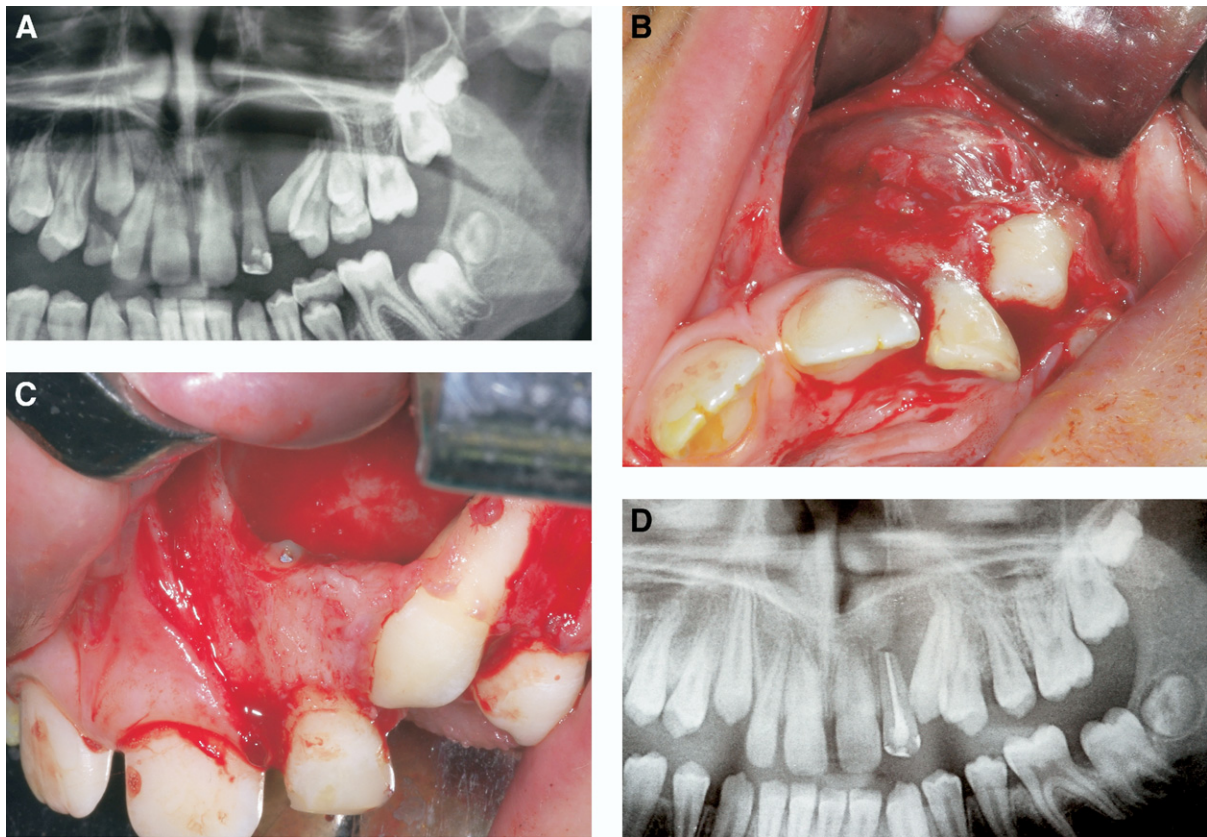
Periapical cyst of the left lateral upper incisor in a 12-year-old boy. A, Orthopantomogram (OPG) showing the radiolucent lesion. B, Intraoperative view of the cyst. C, Apicectomy and retrograde filling of the causative tooth. D, Postoperative OPG after 1 year.
